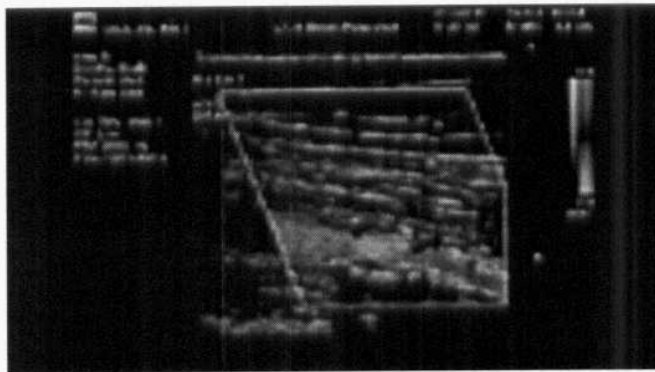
Color Doppler appearance of turbulent flow.
